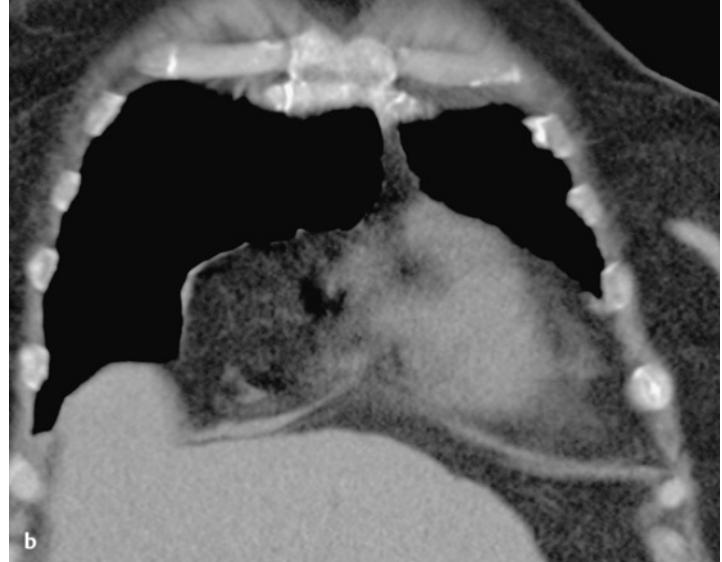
a,b CT visualization of a right paramediastinal fat pad (same patient as in Fig. 1.56). Rightward widening of the pericardial fatty tissue.
